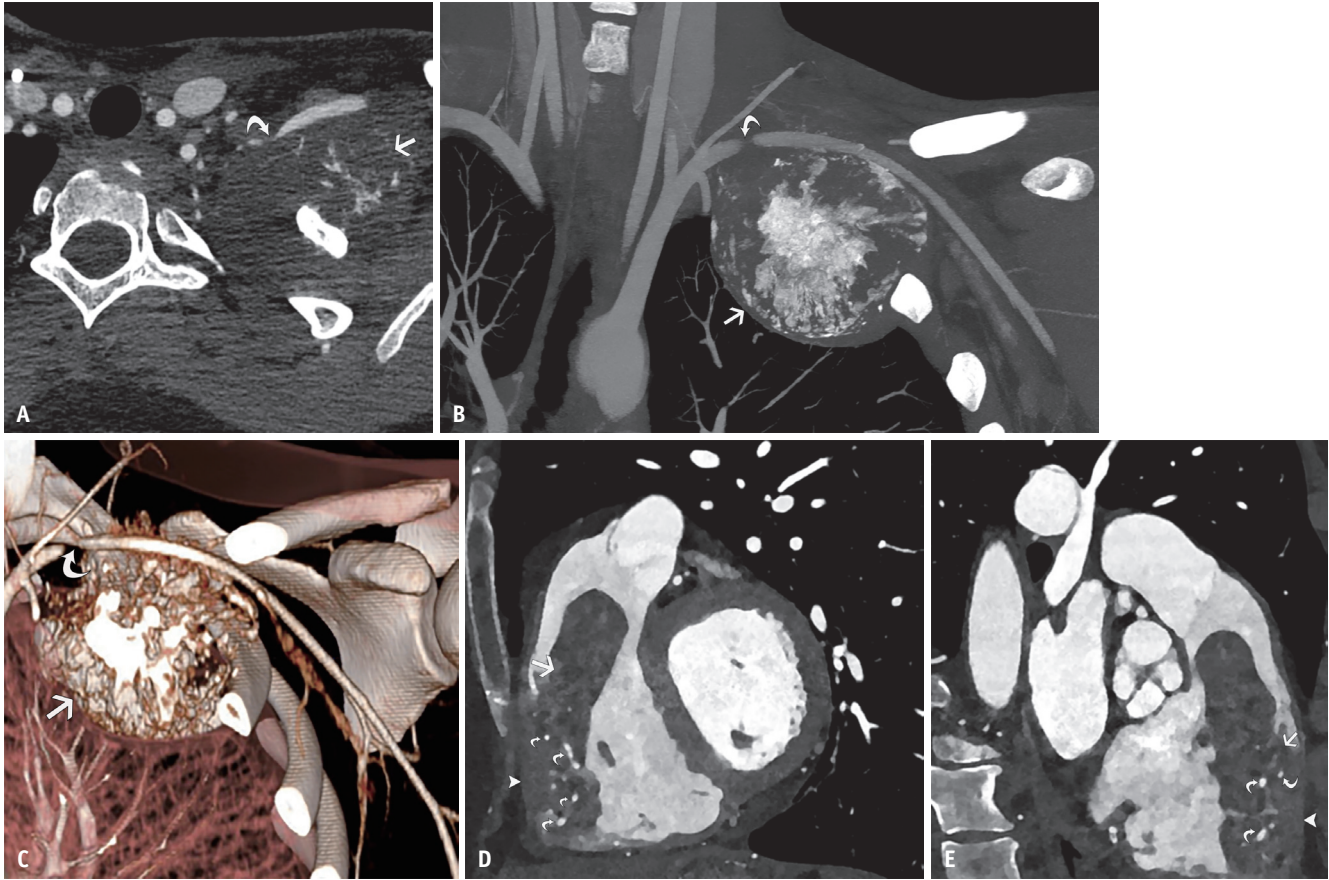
Improved visualization of small vessels. A-C: Axial CTA (A), coronal MIP image (B) and 3D-volume rendered construction (C) from PCCT in a 16-year-old male with osteosarcoma of the first rib demonstrates the mass (arrows) which abuts and severely narrows the left subclavian artery (curved arrows). The tumor was resected, and a graft restored patency. D: Sagittal oblique CTA from PCCT in a 63-year-old male with metastatic hepatocellular carcinoma in the RV shows a mass (arrow) narrowing the RV outflow tract, infiltrating the RV free wall (arrowhead), and supplied by small marginal RCA branches (curved arrows). E: Coronal oblique CTA in the same patient shows the mass (arrow), RV wall infiltration (arrowhead), and feeding marginal branches (curved arrows). CTA = CT angiography, MIP = maximal intensity projection, PCCT = photon-counting CT, RV = right ventricle, RCA = right coronary artery
